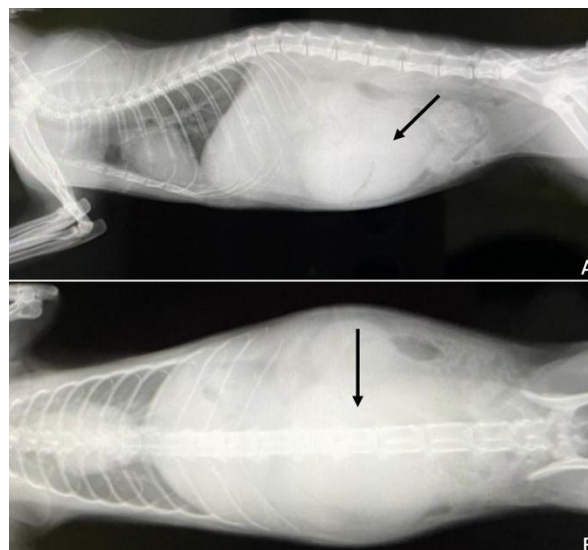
(A-B) Radiographs of the right lateral view (A) and dorsoventral view (B) from the private practitioner revealed a soft tissue opacity mass in an abdomen. (Black arrow).
